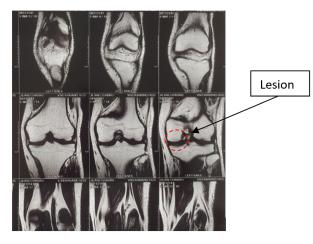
Coronal section of MRI scan showing the defect
